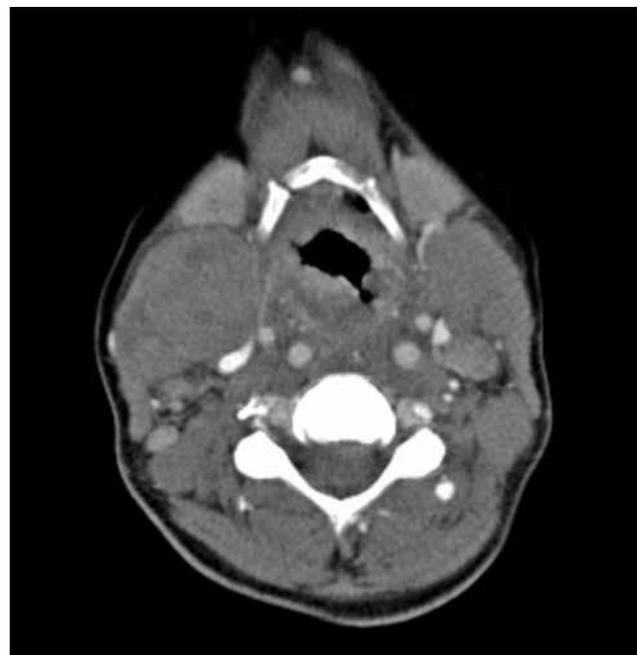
Computed tomography revealed diffuse submucosal nodular thickening narrowing the airway together with bilateral cervical lymphadenopathies.
